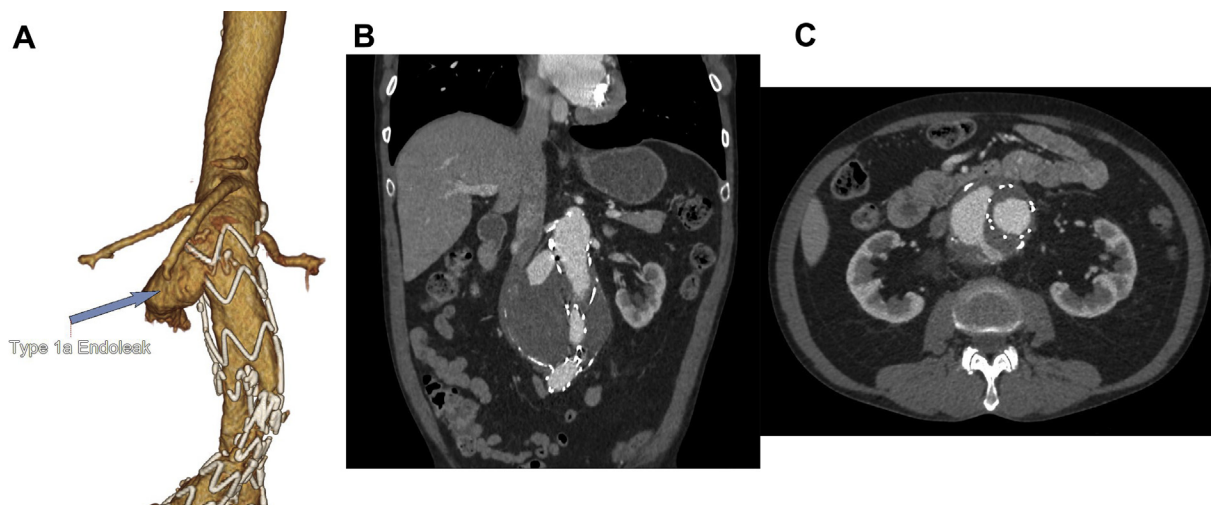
Computed tomography (CT) scan from 2016 showing a type IA endoleak with three-dimensional volume rendered reconstruction (A) and coronal (B) and axial (C) views.
